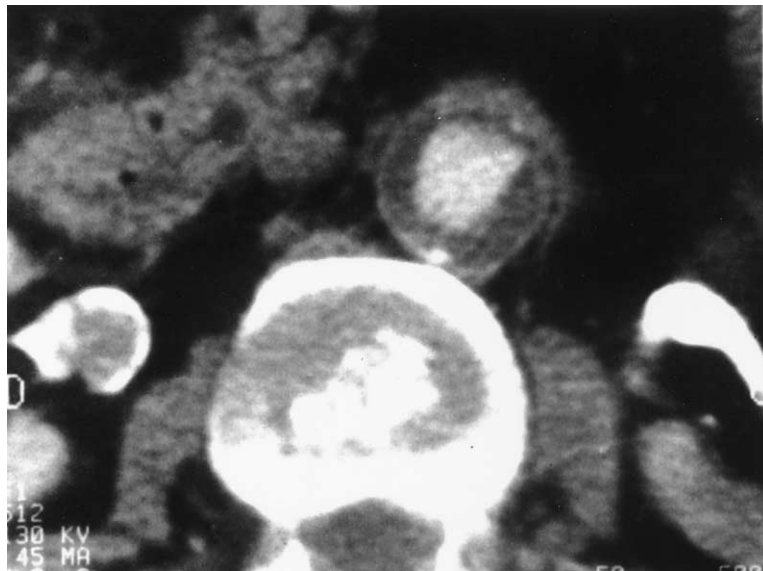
Computed tomography scan demonstrates mild dilatation of the aortic allograft, with mural thrombus, 35 months postoperatively.
